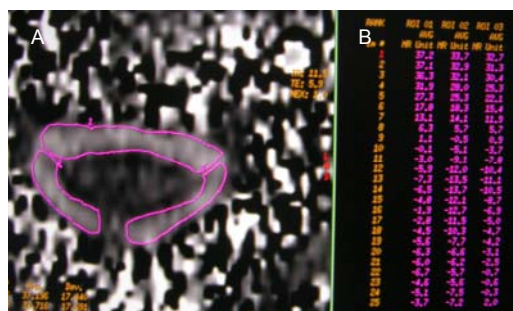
Cervical phase-contrast cine-MRI horizontal axial scanning of real-time flow velocity of cerebrospinal fluid in each phase in ventral, right and left post-lateral subarachnoid space at C₂₋₃ levels.
